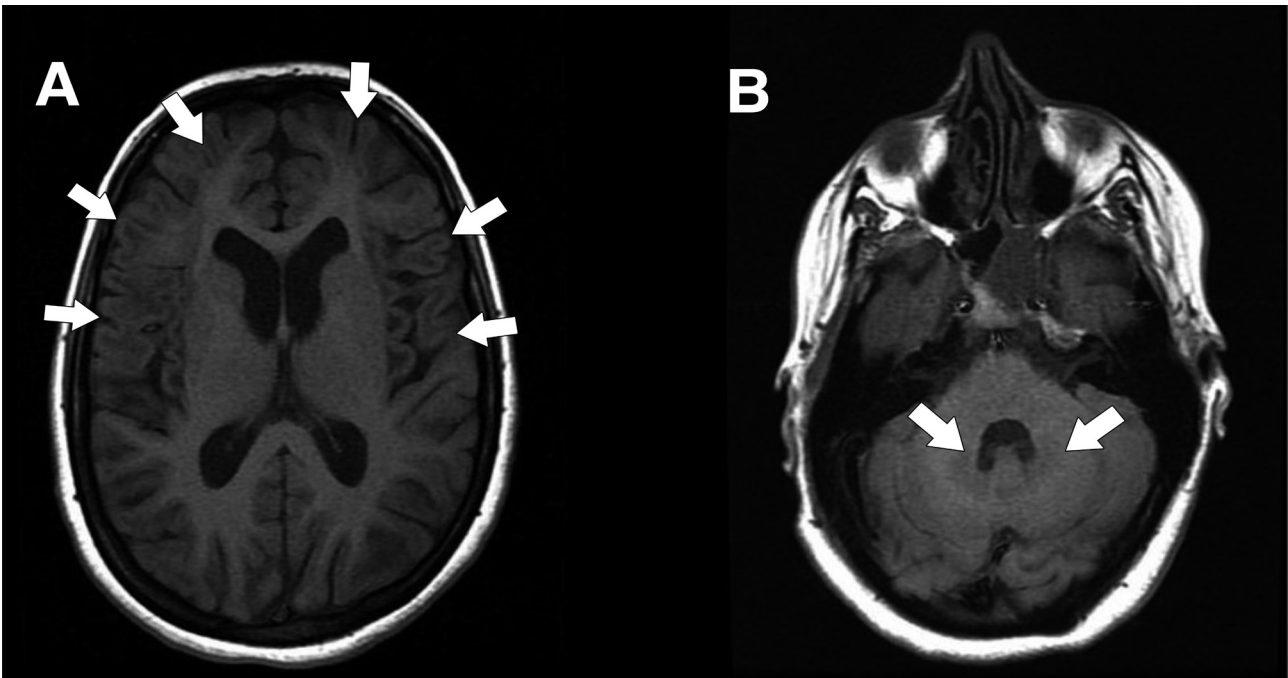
Magnetic resonance axial fluid attenuated inversion recovery (FLAIR) images showing bilateral symmetrical frontal and parietal cortical, subcortical, basal ganglia (A) and dentate nuclei (B) hyperintense signals.
